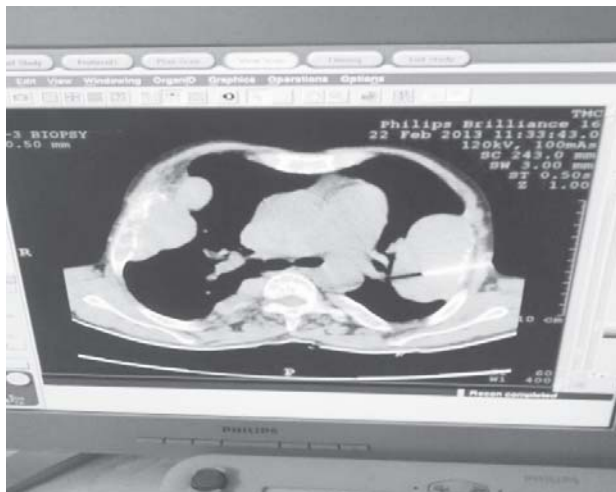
CE CT shows needle inside the mass
